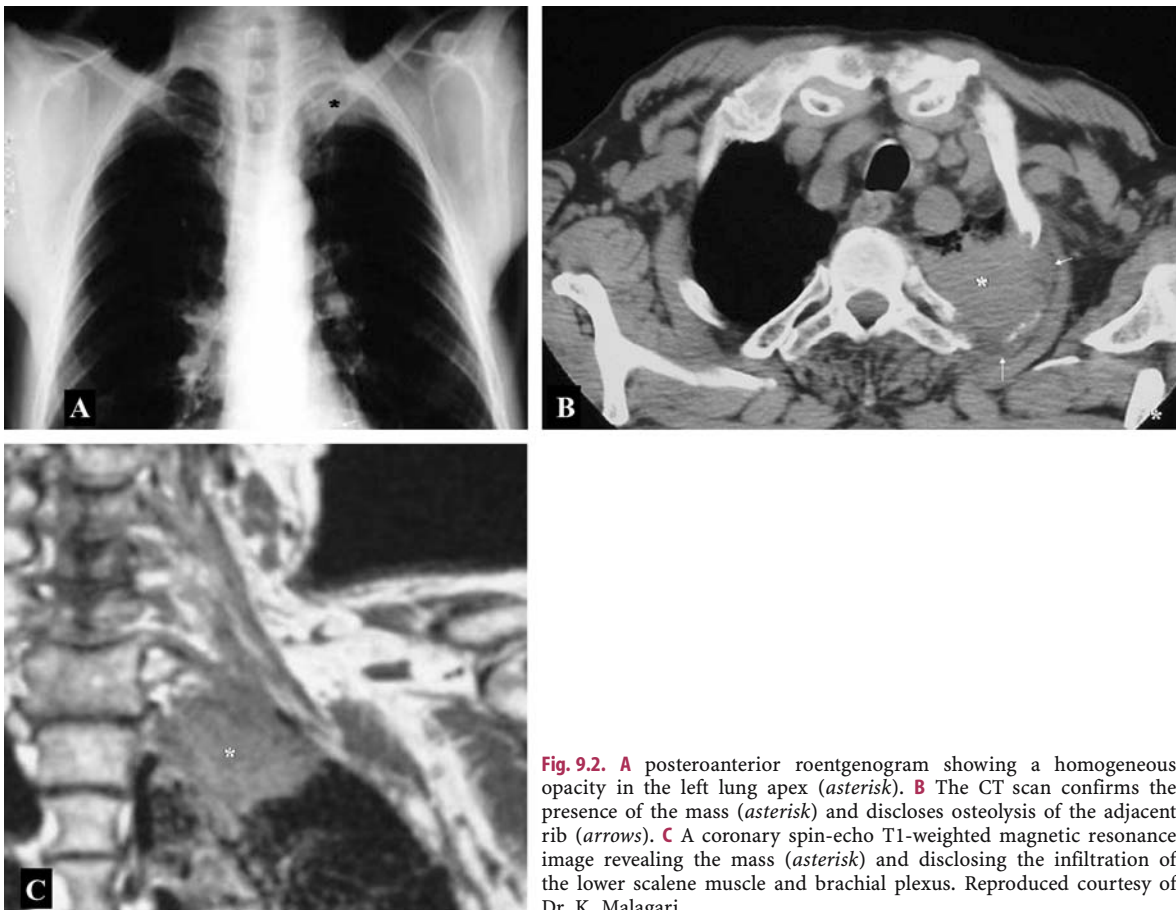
A posteroanterior roentgenogram showing a homogeneous opacity in the left lung apex (asterisk). B The CT scan confirms the presence of the mass (asterisk) and discloses osteolysis of the adjacent rib (arrows). C A coronary spin-echo T1-weighted magnetic resonance image revealing the mass (asterisk) and disclosing the infiltration of the lower scalene muscle and brachial plexus. Reproduced courtesy of Dr. K. Malagari
